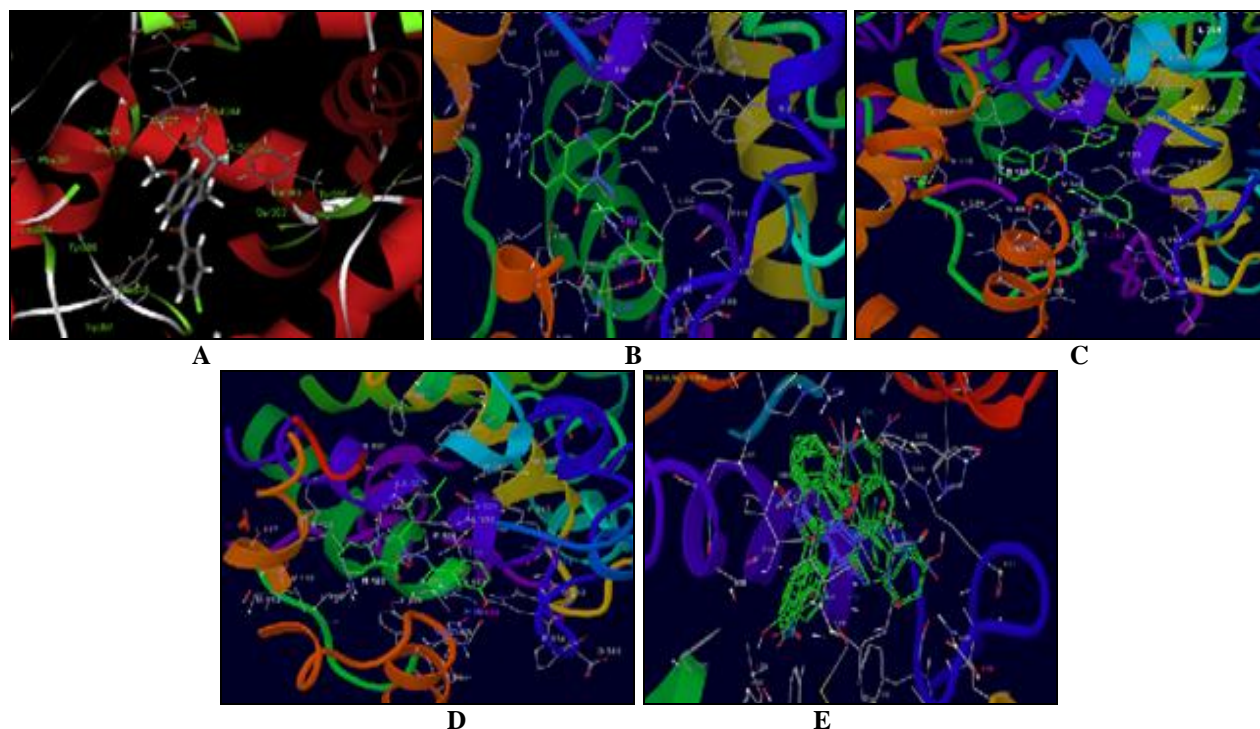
COMPOUNDS SHOWING INTERACTION WITH HIS-90; 3A- INTERACTION OF INDOMETHACIN WITH ARG-120; 3B, 3C AND 3D- COMPOUNDS 8, 11 AND 14 SHOWING INTERACTIONS WITH HIS-90 AT THE H-BOND DISTANCE OF 1.788, 1.843 AND 2.000 Å RESPECTIVELY
